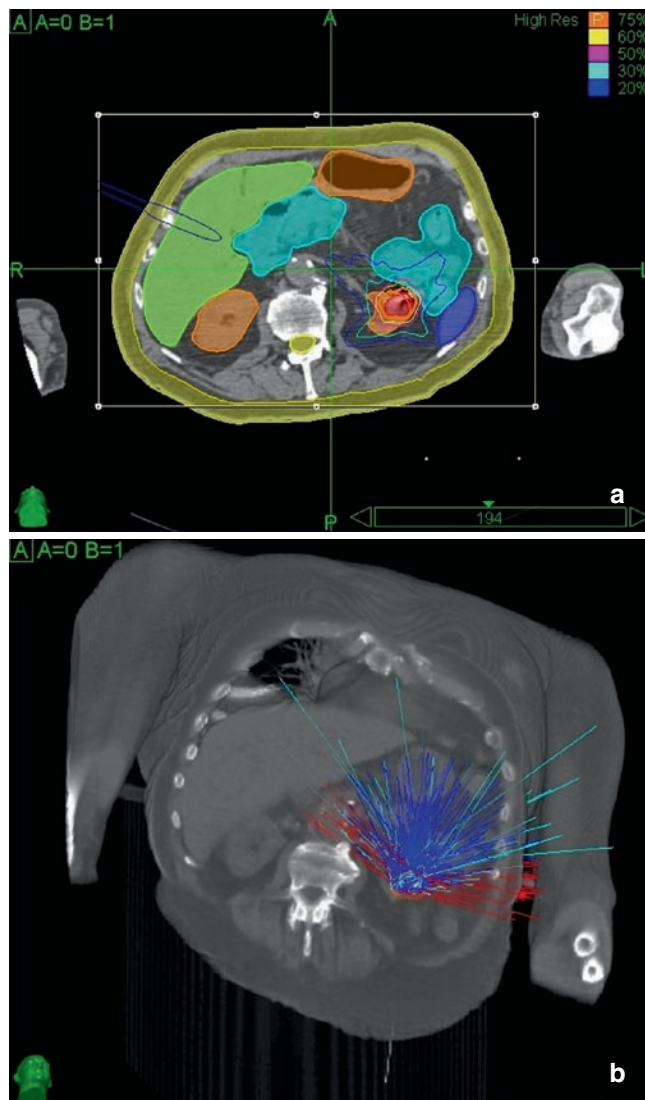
Preprocedural planning CT. (a) Using the treatment planning software, the normal organs are outlined so as to direct the beams for dose-limiting purposes; the left renal tumor and treatment zones are mapped. (b) The planned beams are directed from multiple angles so as to limit the dose received by the normal organs in their paths
